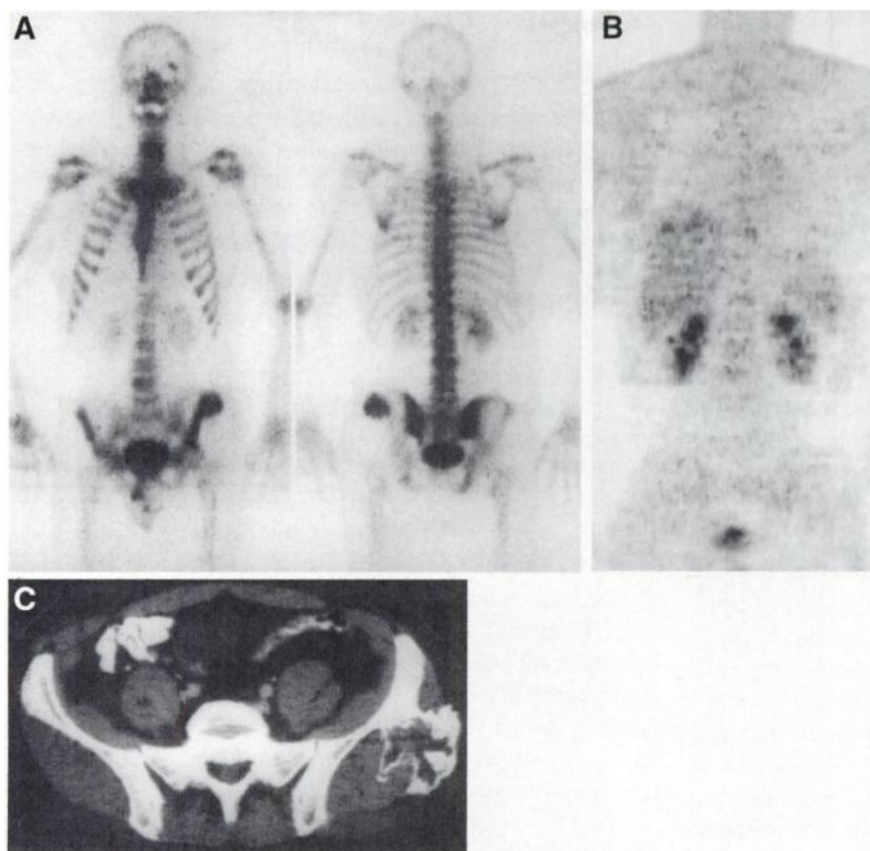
(A) ^{99m}Tc -diphosphonate scintigrams show intense and eccentric lesion in left ilium and (B) normal glucose metabolism on FDG PET. (C) Unchanged visualization on CT follow-up examination confirmed benign nature of this lesion.
